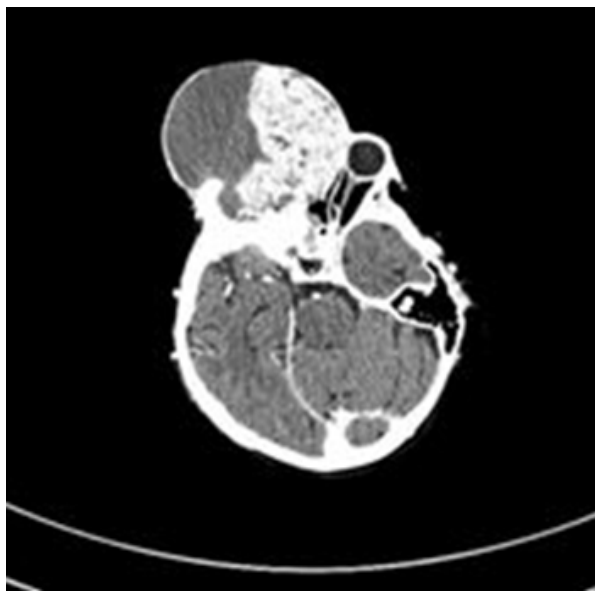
Head and maxillofacial computed tomography (CT) scan before the start of sonidegib therapy.
